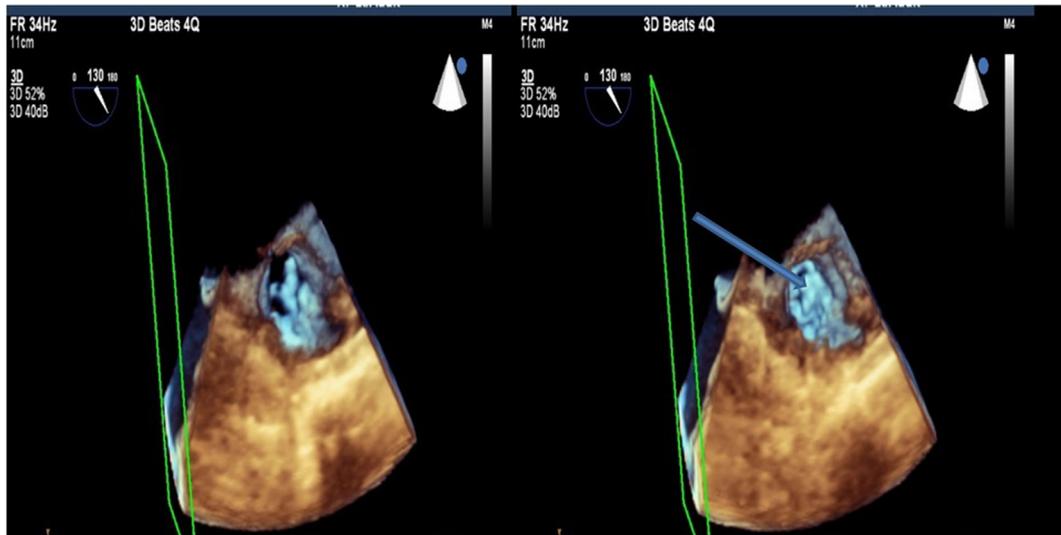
Assessment of the aortic prosthesis vegetation with the help of three-dimensional (3D) transoesophageal echocardiography (TEE).
